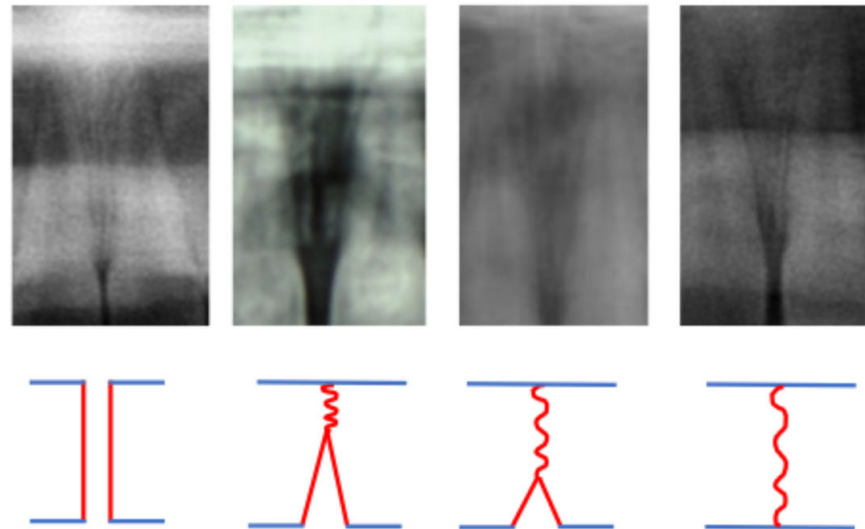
Representation and classification of four categories of ossification of the midpalate suture, defined according to the radiographic appearance of the suture on OPGs.
